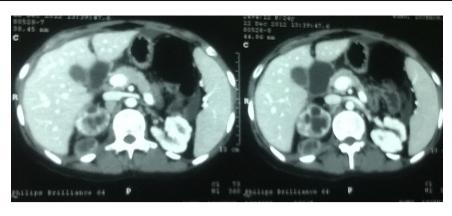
CT scan revealing right-sided hydronephrosis with collection within the calyceal system and poor renal function.
